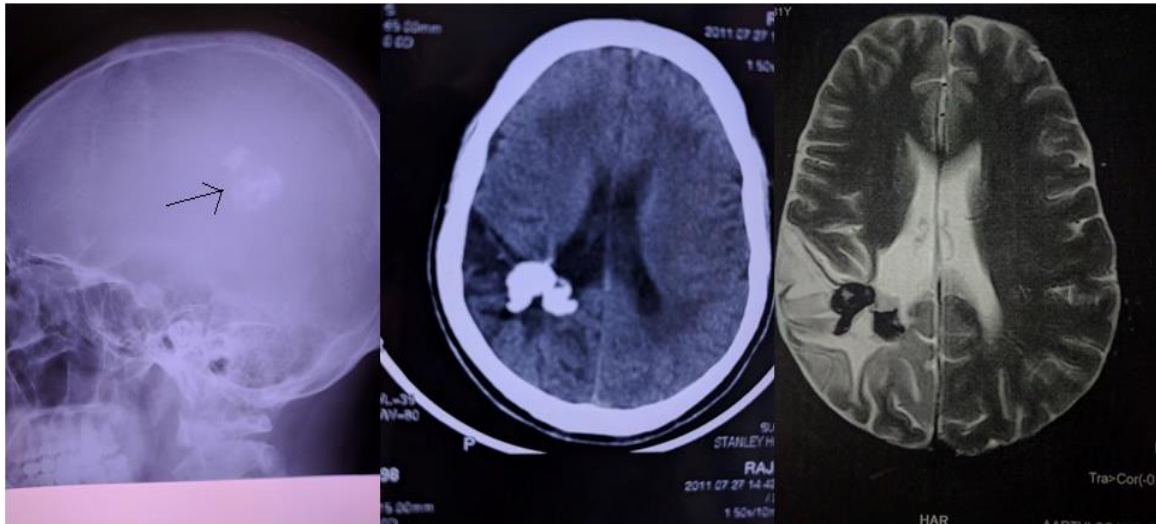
MRI (brain) of 36-year-old male with cavernous hemangioma in right medial temporal region
